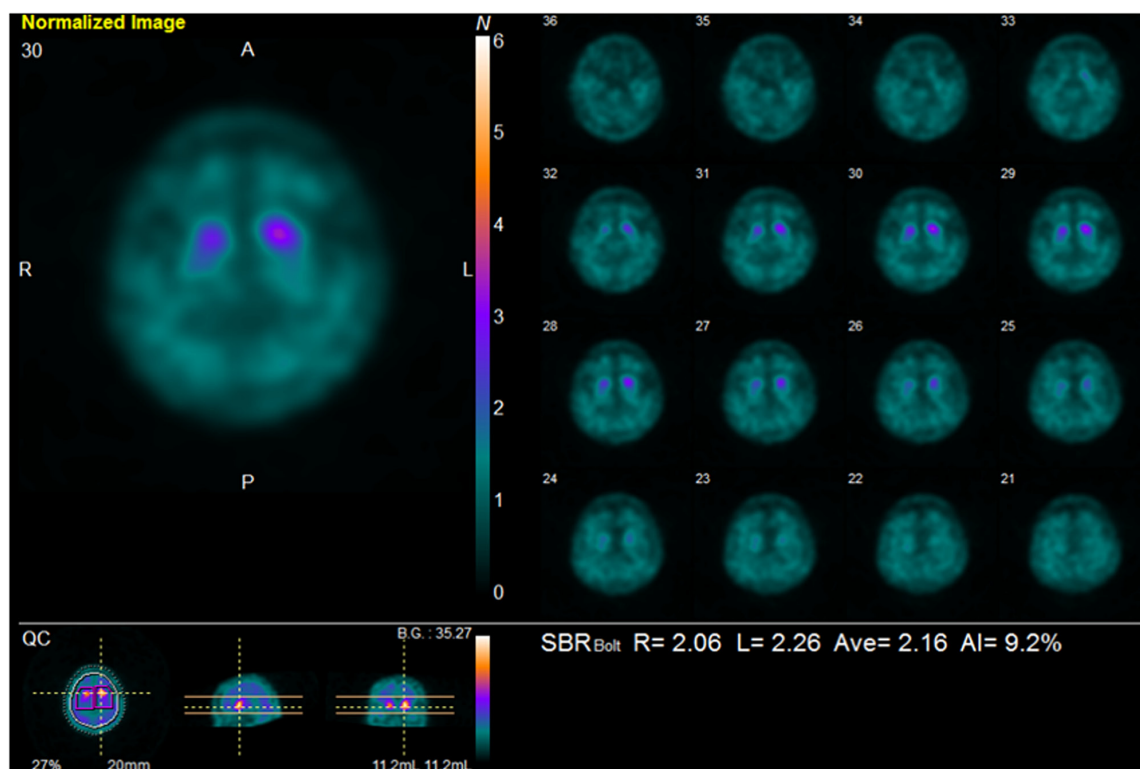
^{123}I -ioflupane SPECT results from December 2017. ^{123}I -ioflupane SPECT data show reduced bilateral striatal uptake. Specific binding ratio: 2.16 (right, 2.06; left, 2.26); asymmetric index: 9.2 (%). SPECT, single-photon emission computed tomography.
